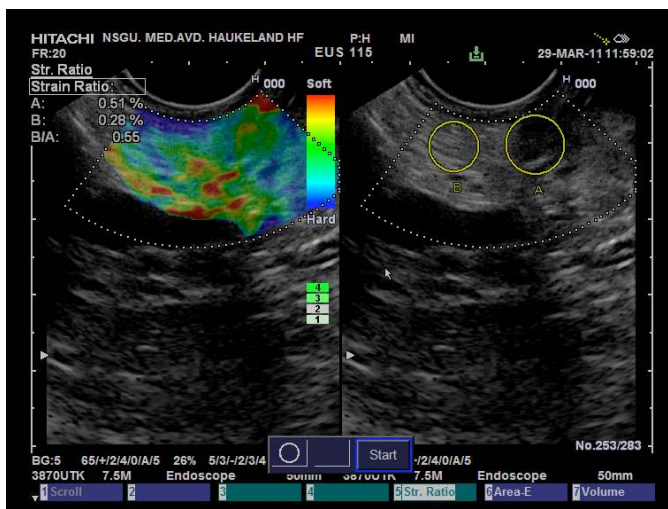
Endoscopic elastogram (left) and B-mode sonogram of a solid, hypo-echoic lesion in the body of the pancreas. The lesion is being measured with strain ratio marked on the B-mode image (right); dividing mean strain in circle B (reference) with mean strain in circle A (lesion) yields a SR of 0.55, indicating that the lesion is softer than the pancreatic reference tissue. Diagnosis after follow-up: Sequelae of pancreatitis.
